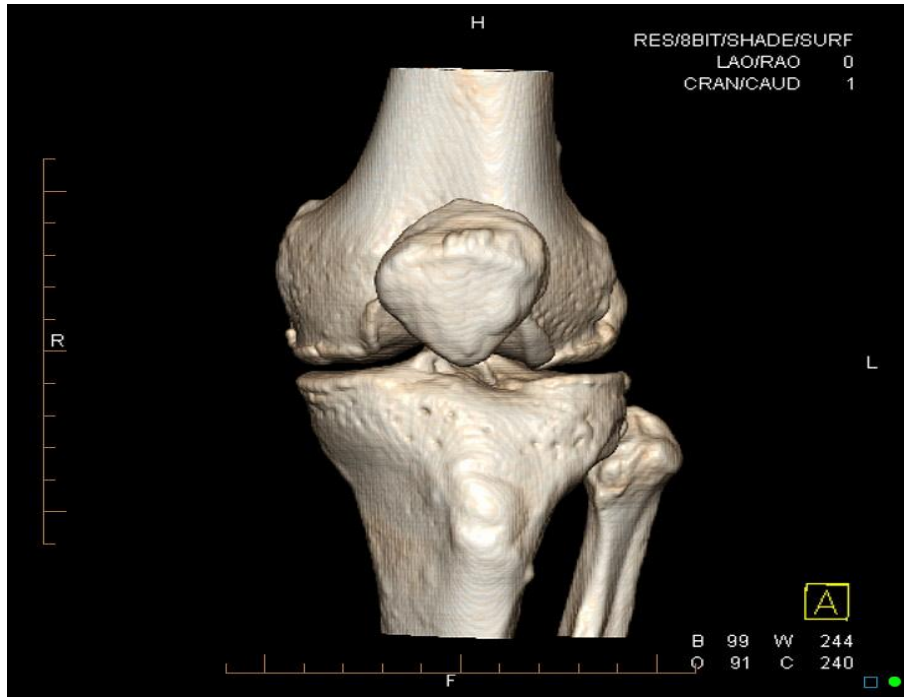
Shows axial CT image of the knee joint ([Http://www.gentili.net/FBI/images/tibplateauct3.jpg](http://www.gentili.net/FBI/images/tibplateauct3.jpg)).
